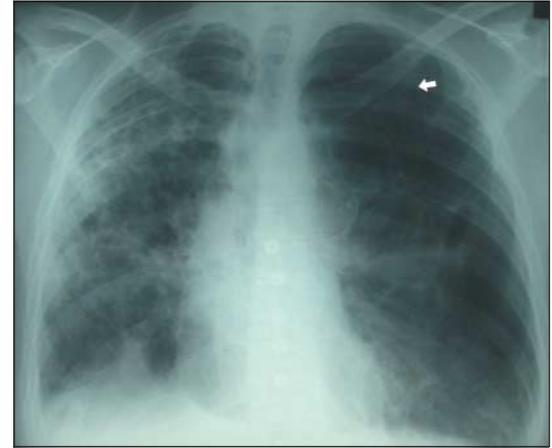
Background fibrotic lung disease (underlying ulcerative colitis), which places patient at risk of secondary pneumothorax. Although medial border of scapula (arrow) is easily recognisable as such on this radiograph it can sometimes be misinterpreted as a visceral pleural line
